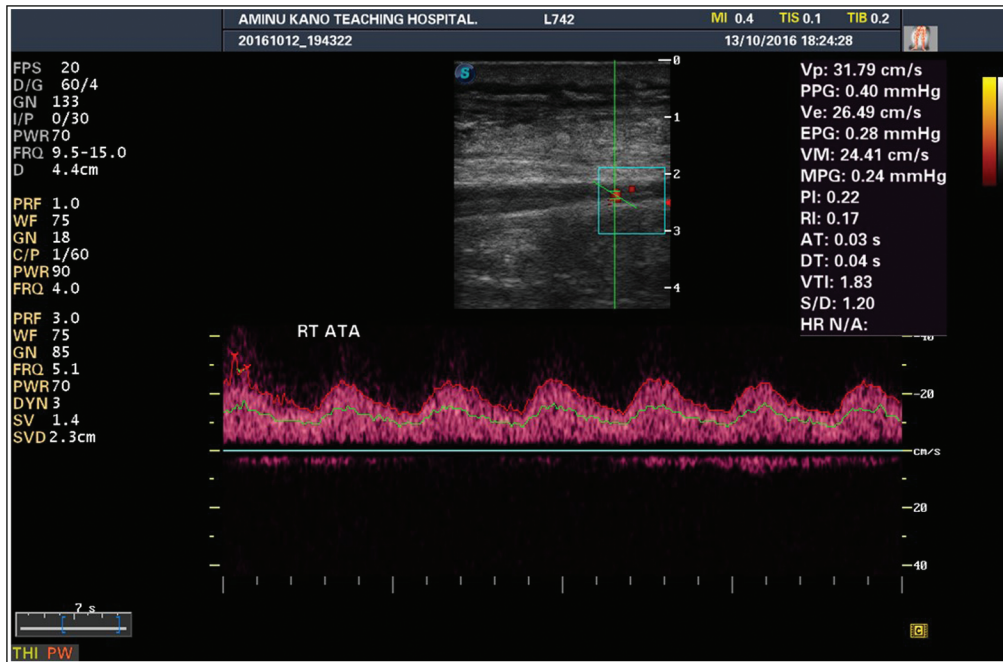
A spectral Doppler sonogram of the right anterior tibial artery (ATA), showing a dwarf systolic peak, spectral broadening and significant diastolic blood flow. These features are typical of the significant proximal stenotic disease
